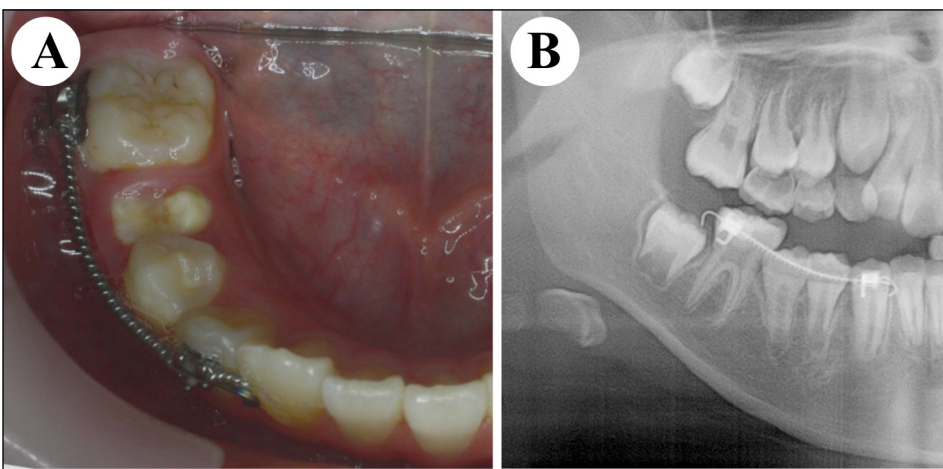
Movement of the tooth after 3.5 years. A, Intraoral appearance. B, Panoramic radiograph.
